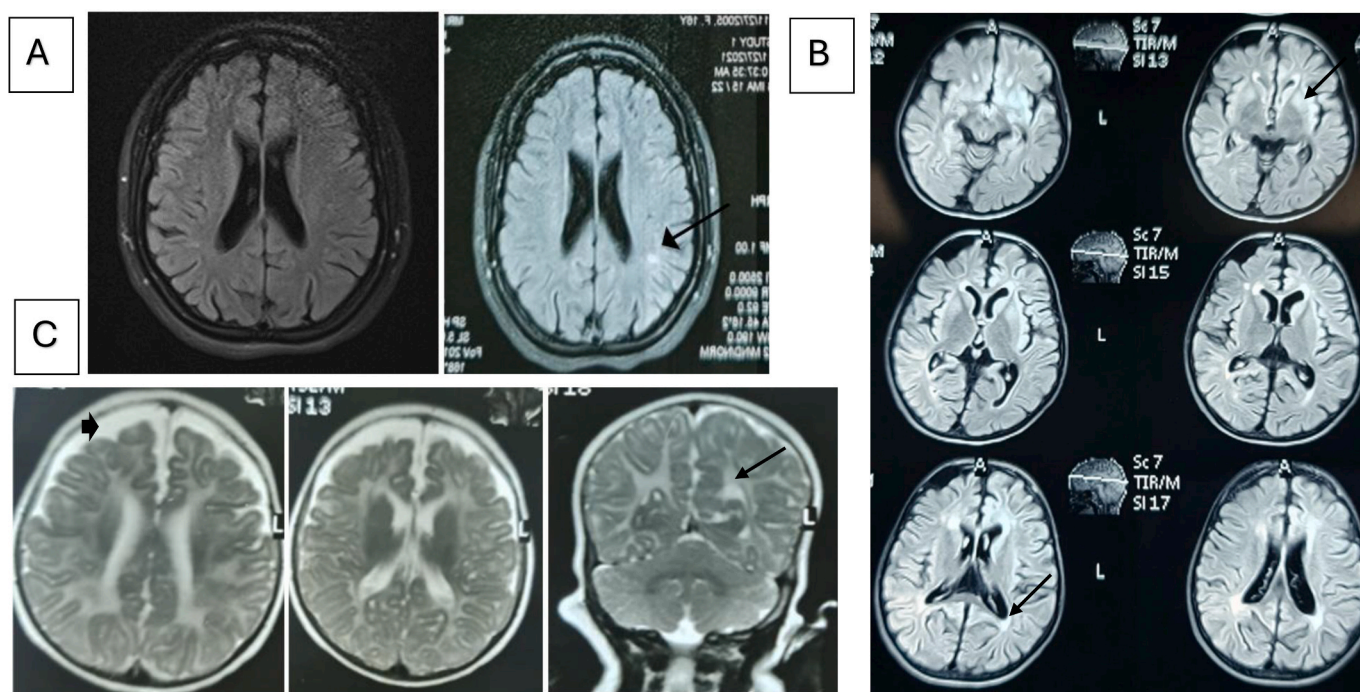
(A) Patient no. 5: A 15 - year - old female, suffered from psychomotor delay and abnormal behaviour which led to her condition progressing and eventually ending in a nonambulatory state. Brain MRI (axial/FLAIR) shows multiple asymmetrical subcortical white matter lesions with high signal intensities in the posterior region associated with generalised mild brain atrophy and dilated lateral ventricle. She had confirmed genetic variant in *MTHFR*. (B) Patient no. 1: A 10-year-old girl presented with neuro-regression, decreased school performance and seizure. Brain MRI (axial / FLAIR) shows high signal abnormalities in the periventricular and deep white matter (anteriorly and posteriorly), basal ganglia (caudate and putamen) (black arrows on both areas), and mild and generalised brain atrophy. She had a confirmed genetic variant in *MMACHC*. (C) Patient no.14: A 5 – year – old female, presented with neuro-regression started at one year, abnormal gait, and abnormal behaviour. Brain MRI (axial and coronal T2WI) shows bilateral symmetrical diffused increased signals of white matter (black arrow) (periventricular, deep and subcortical) with decreased white matter volume and atrophic changes that are more prominent at the frontal areas (black arrow head). He had a confirmed genetic variant in *MTHFR*.
